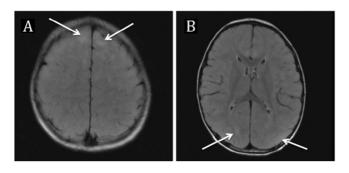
Brain magnetic resonance imaging 1 week after patient presentation. Axial T2 fluid-attenuated inversion recovery image shows A, bifrontal hyperintensities in the cortex and subcortical white matter (*arrows*) and B, hyperintensity in the left parietal cortex and occipital subcortical white matter (*arrows*).
